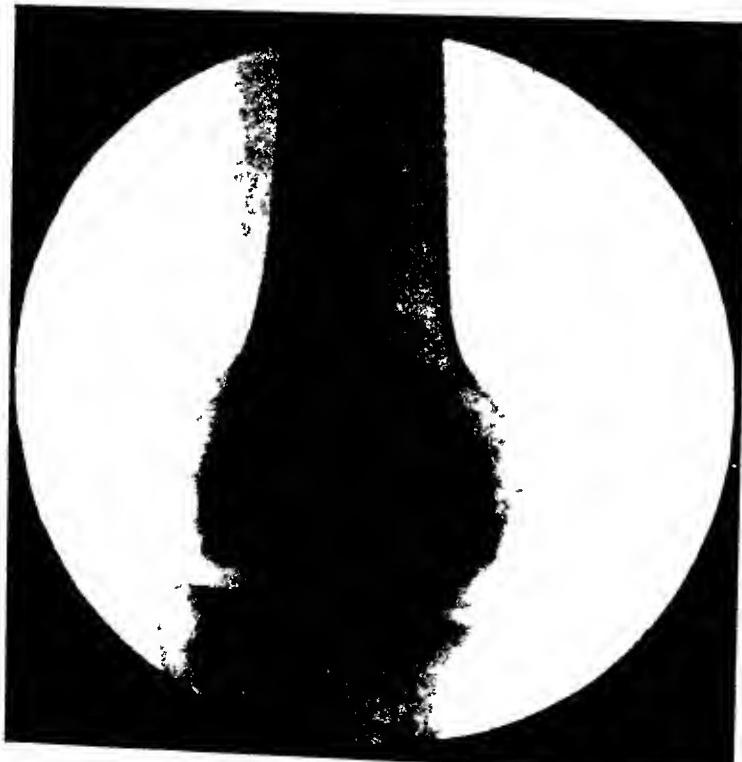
Case II. Pathol. No. 34522. X-ray taken in 1920 and diagnosed a benign ossified lesion.
